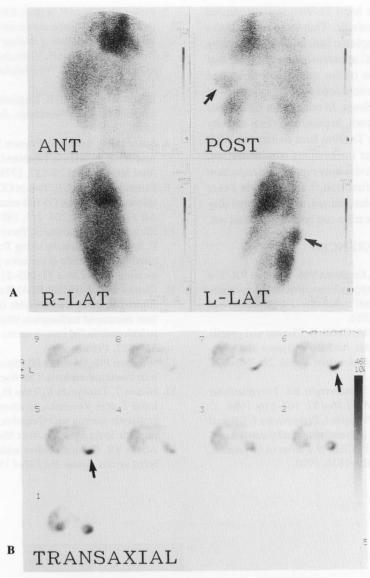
Tc-99m heat-denatured RBC planar (A) and SPECT (B) images taken at 1 hour after intravenous administration show an obvious splenic activity (arrow). A substantial amount of cardiac blood pool, hepatic and renal activity is also noted.
